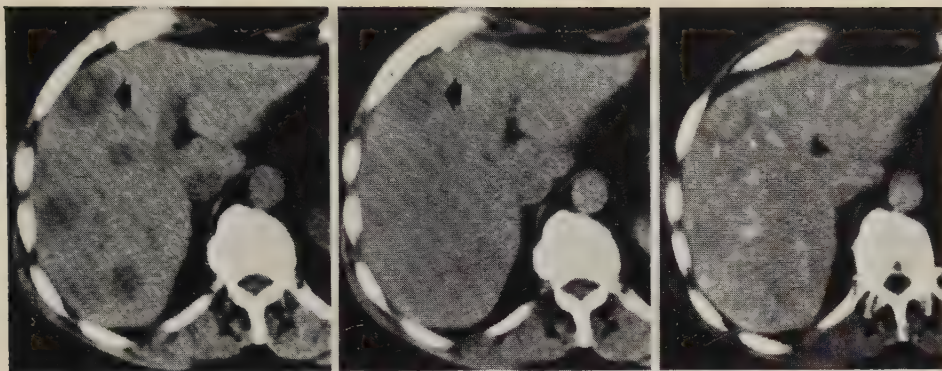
Patient with liver metastases from colon carcinoma: A/ Unenhanced CT examination shows multiple hypodense lesions in the right liver lobe, one of which with a central higher density (arrow). B/ The same CT slice after intravenous contrast enhancement. The lesion still appears hypodense but almost uniform (arrow). Other lesions have changed almost to isodensity compared to the surrounding liver parenchyma. C/ After intraarterial contrast enhancement (via a catheter in the celiac axis) the lesion turns isodense to liver parenchyma but is surrounded by a low density ring (arrow heads). Other lesions are only faintly visible.
